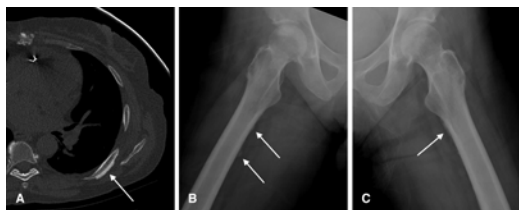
(A) CT chest demonstrating periostitis in a left posterior rib. Frog-leg views of the right (B) and left (C) femur from a radiograph bone survey demonstrate multiple foci of periostitis.
